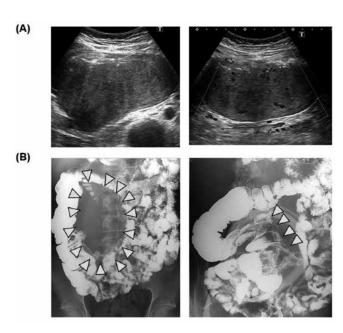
(A) Abdominal ultrasonography shows an iso-low, homogeneously echoic large tumor. Blood flow is confirmed.
